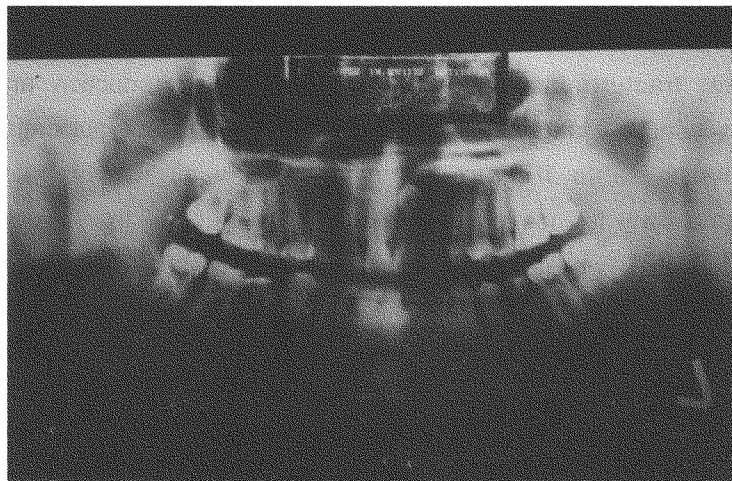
The x-ray showed bilateral condylar fracture dislocation. Note the head of condyles is out of the joint socket.
